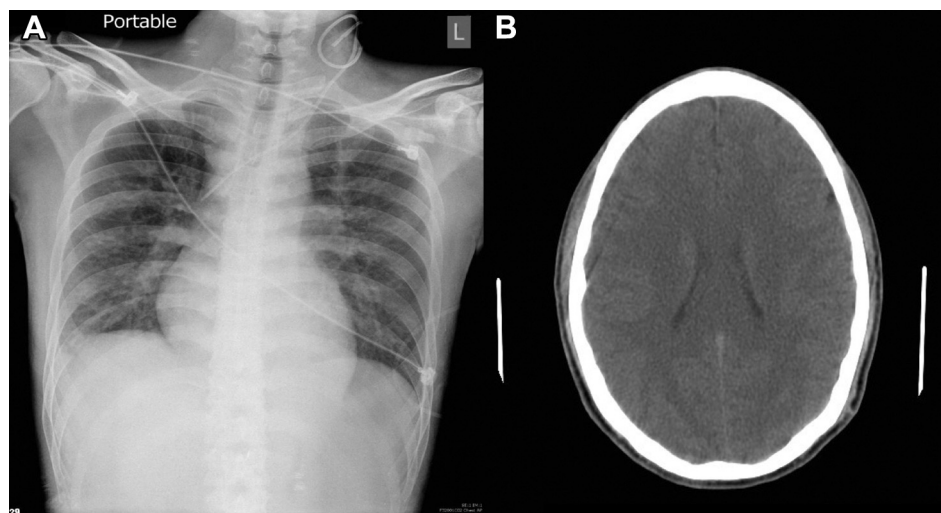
(A) Chest X-ray showing signs of interstitial infiltration of bilateral lower lobes of lungs. (B) Brain computed tomography scan showing edematous change of brain tissue.
